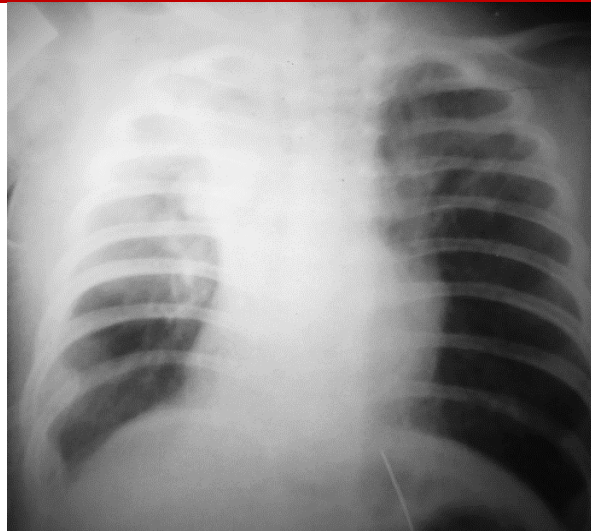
Patient F.Sh., 1 year 1 month, medical record number 614-52. Post-lobectomy status with partial atypical resection for right CCAM. Plain chest radiograph - partial expansion of the remaining lung.
